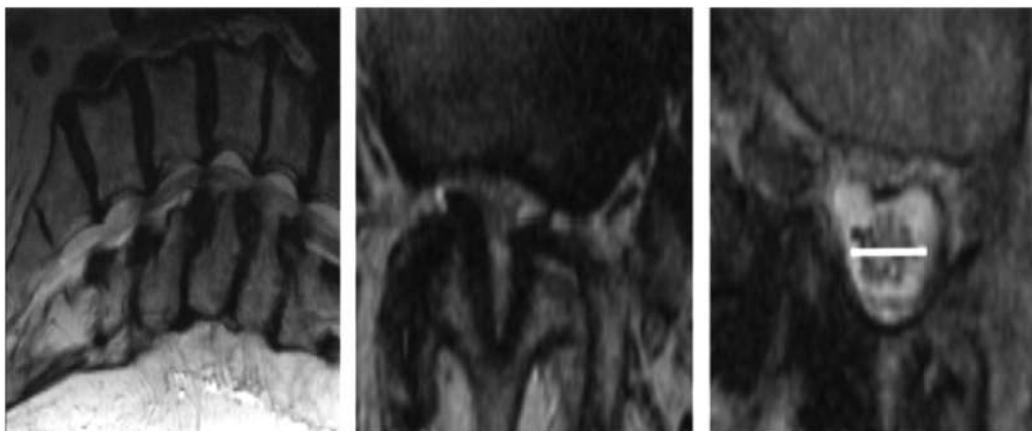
MRI scans of a patient with a positive sedimentation sign. Left, Absolute stenosis at level L3/4 (T2, female, 66 years, treadmill test 35 m). Centre, Cross-sectional area of narrowest segment at level L3/4 50 mm². Right, Positive sedimentation sign above level L3/4.
